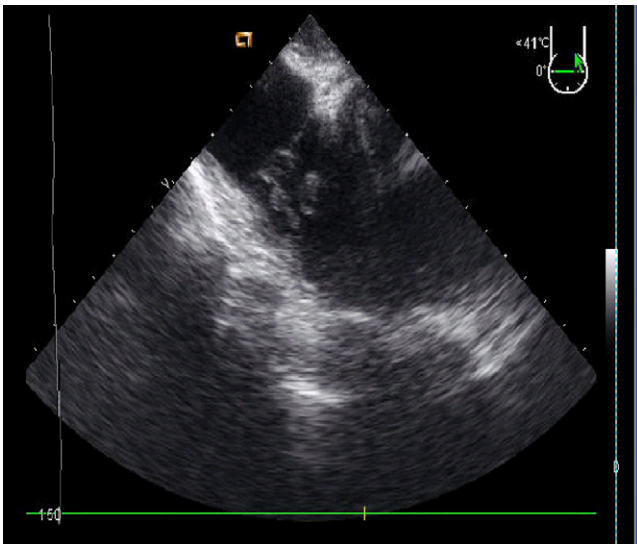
Transesophageal echocardiography showing vegetation in tricuspid valve.
